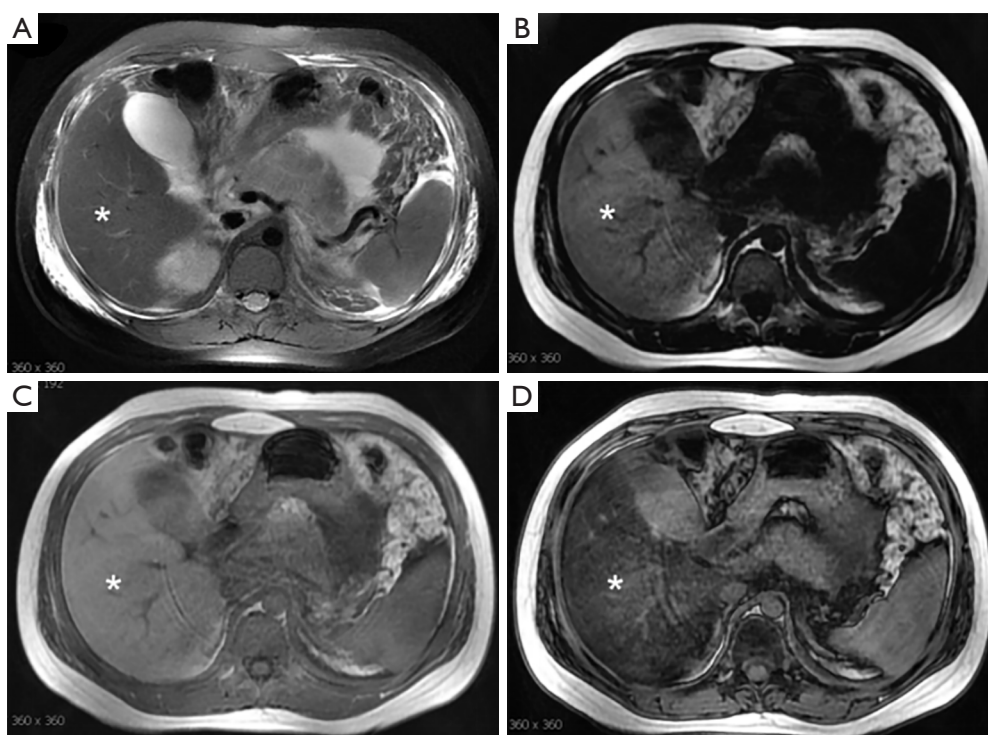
A 44-year-old male patient with acute pancreatitis and fatty liver. The MRI T2WI shows fluid collections around the pancreas (A). On the LAVA-Flex fat-only phase image (B), the liver intensity is high (asterisk). In addition, the intensity of the liver parenchyma on the in-phase image (C) is significantly higher than that on the out of phase image (asterisks) (D). MRI, MR imaging.
